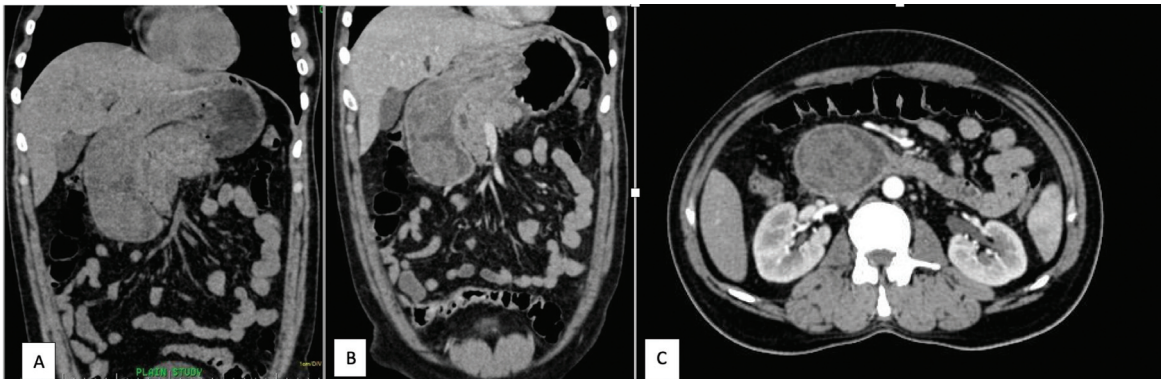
(A–C) Plain and contrast computed tomography scan showing a large polypoidal enhancing mass from body of stomach dragging the stomach into the duodenum.
